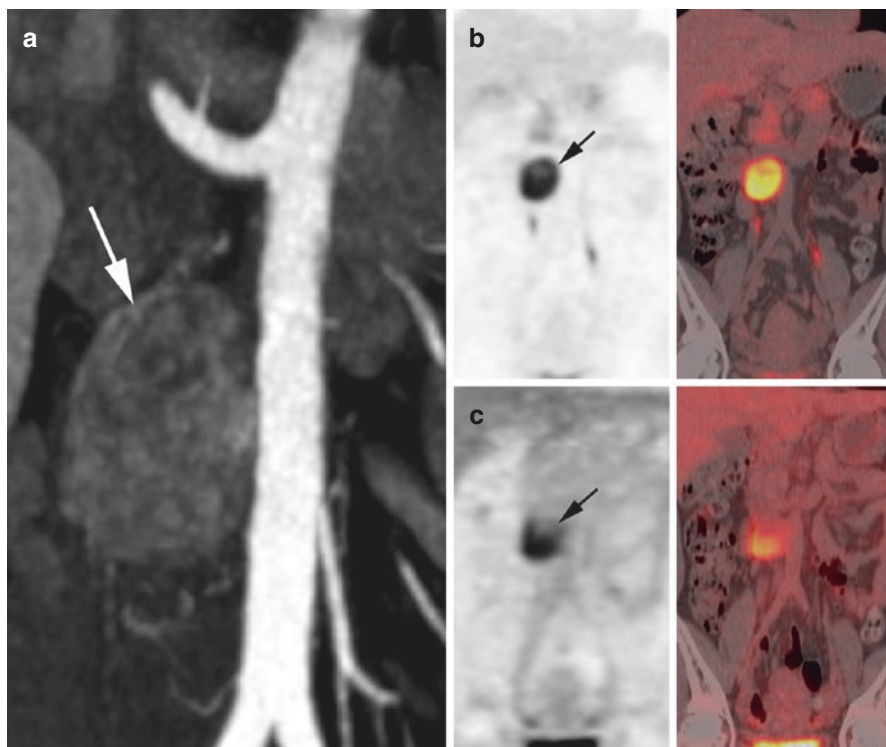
HIF2A*-related paraganglioma of the organ of Zuckerkandl. Contrast-enhanced CT arterial phase (a) showing a hypervascular and heterogeneous left para-aortic mass located at the level of the inferior mesenteric artery (arrow). ^{18}F -FDOPA PET/CT (b) and ^{18}F -FDG PET and PET/CT (c) showing a single tumor with heterogeneous uptake and a preferential ^{18}F -FDOPA imaging pattern, a finding which is opposite to the classical *SDHx*-associated imaging phenotype (see Fig. 14.7)
